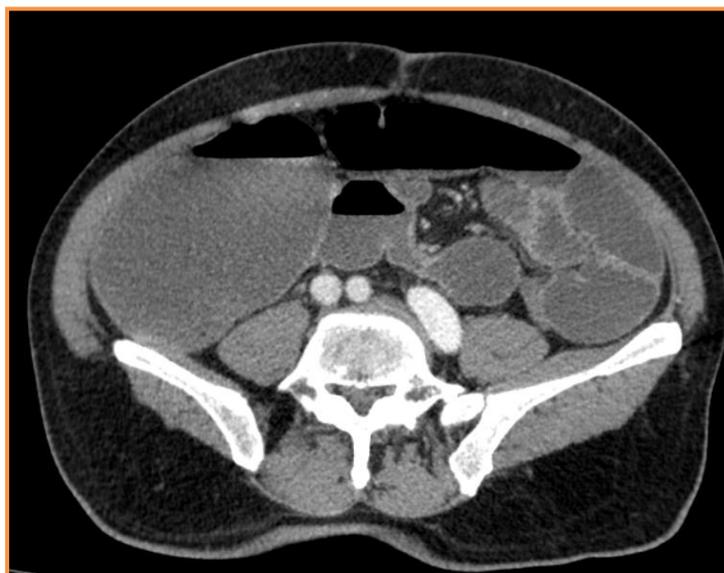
Abdominal CT scan in axial section shows a mixed hydro-aeric distension site of hydro-aeric levels
